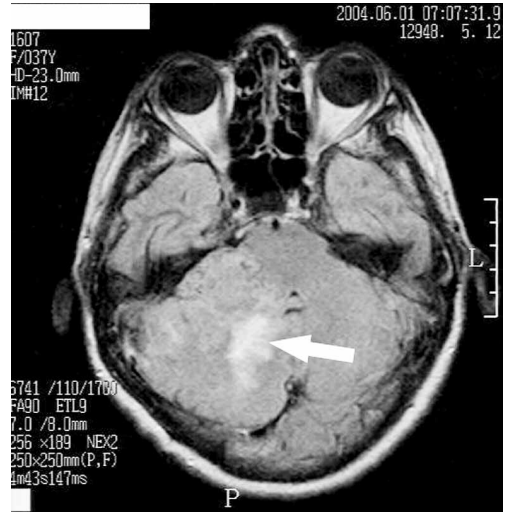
Axial FLAIR-weighted image (IR, 6741/110/1700) reveals ill-defined area of the increased signal intensity occupying the right cerebellar hemisphere with perifocal white matter oedema (arrow).
